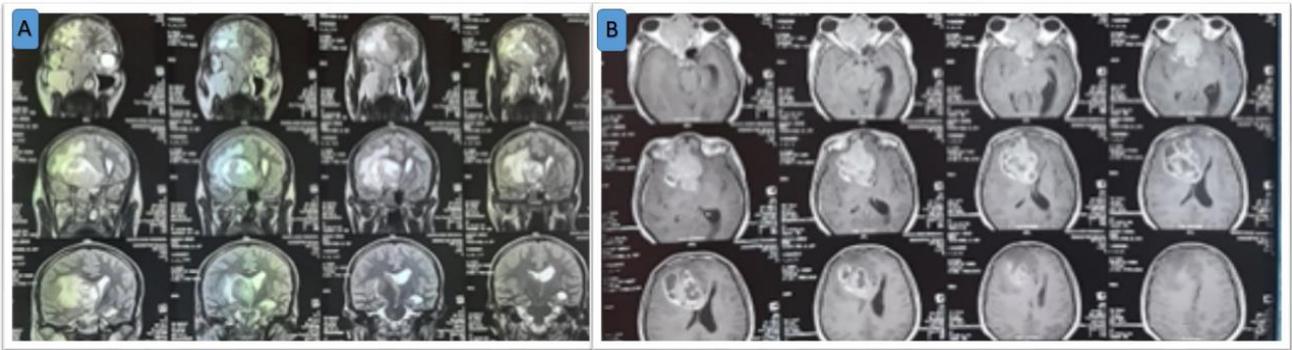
Craniocervical MRI; A) MRI frontal section T2 sequence, B) MRI axial section T1 sequence
